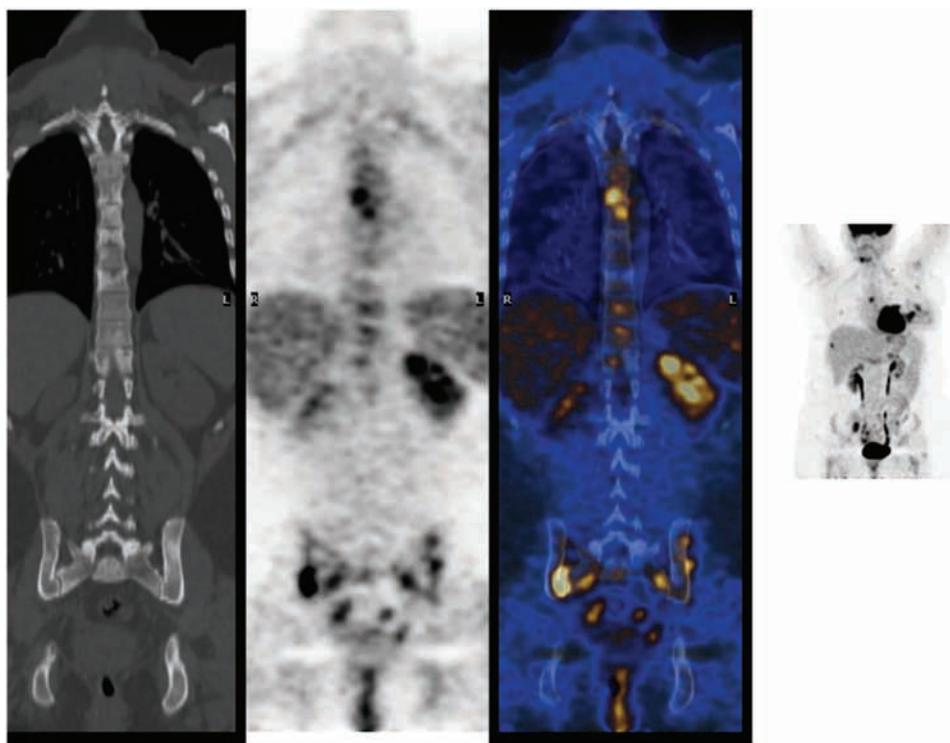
Comparison of bone scan and PET/CT. Note different sites of disease.
